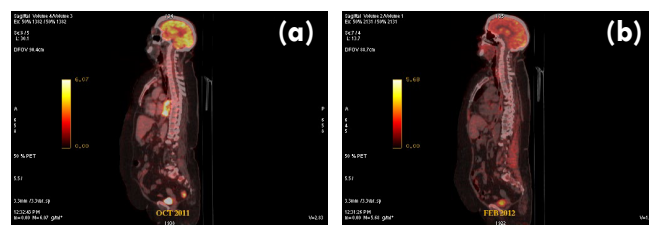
(a): Sagittal fused image showing esophageal lesion with increased FDG uptake (before treatment). (b): Sagittal fused image, corresponding to figure 3A showing near complete metabolic resolution with regression in wall thickening (after treatment).
